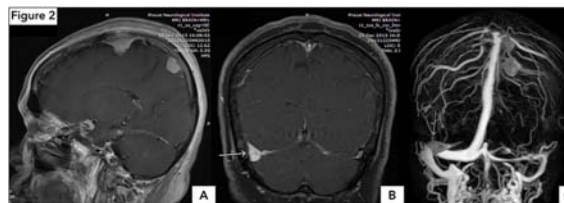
Sagittal and coronal MRI with gadolinium enhancement demonstrate multiple small meningioma (A&B). Tumor at right transverse sigmoid junction compresses the venous sinus and creates the high intracranial pressure (C).
